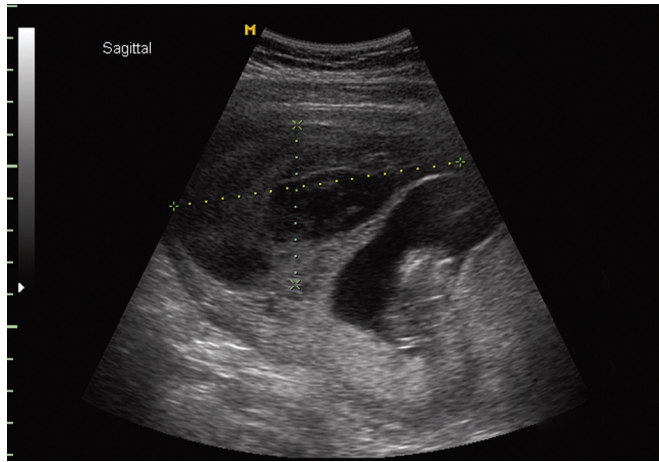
Ultrasonic image of a subchorionic abruption. (Courtesy K. Francois.)
